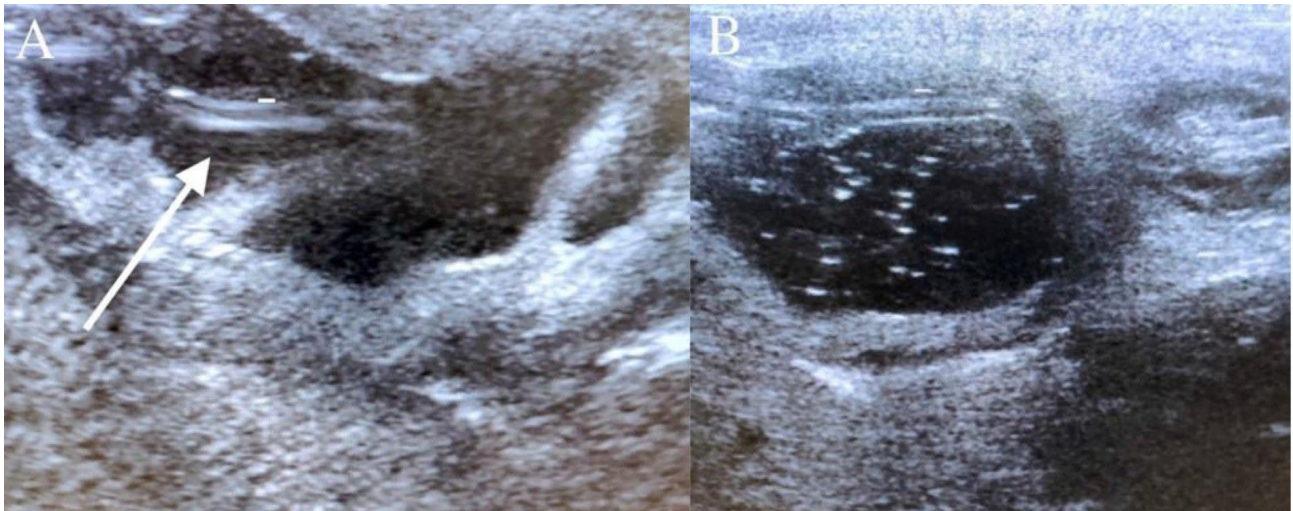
Ultrasonogram of *T. vitulorum* parasites. (A) In longitudinal section, *T. vitulorum* parasites are seen as two hyperechoic lines resembling “train rails” (see arrow) and, hyperechoic cross-section view of *T. vitulorum* (B).
